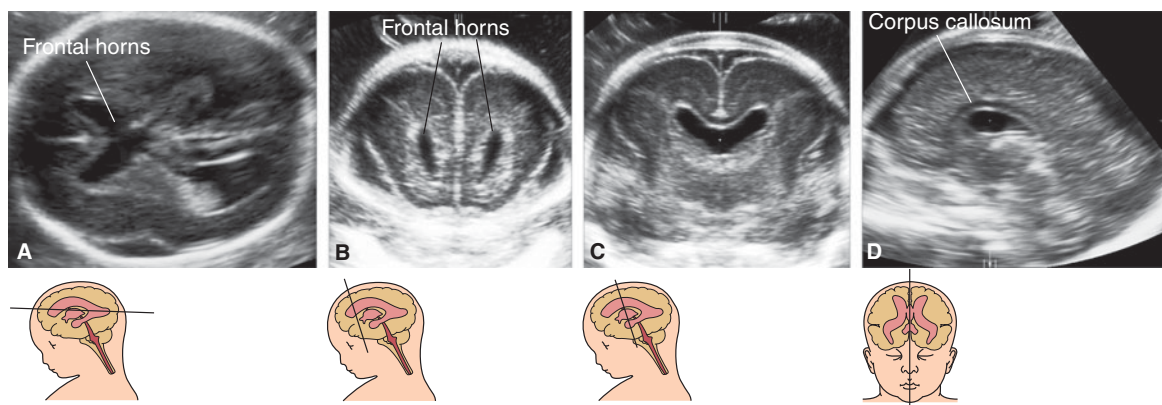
Agnesis of the septum pellucidum. In this case, a differential diagnosis than lobar holoprosencephaly is possible by demonstrating in the axial plane (A) as well as in an anterior coronal plane (B) that the frontal horns are separated anteriorly, with a well-developed IHF between the anterior hemispheres. The demonstration of a normal corpus callosum also favors the diagnosis of agnesis of the septum pellucidum. (Reproduced, with permission, from Tutschek B, Piliu G. Virtual reality ultrasound imaging of the normal and abnormal fetal central nervous system. *Ultrasound Obstet Gynecol.* 2009 Sep;34(3):259–267.)
